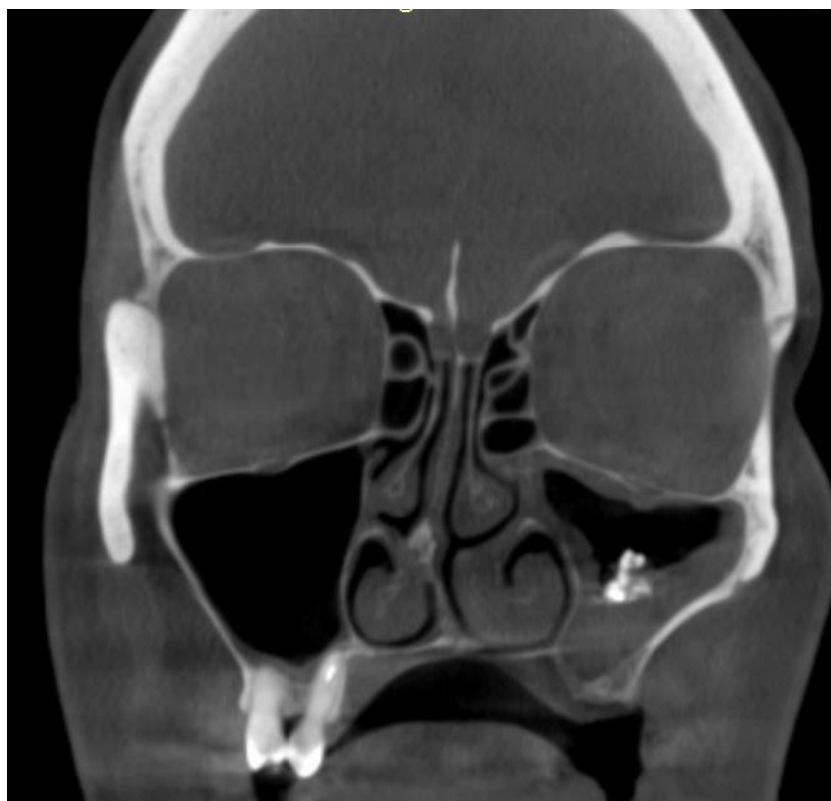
Patient D.; cone beam computed tomography of paranasal sinuses before surgery; the crest of the nasal septum, the decrease in pneumatization of the left maxillary sinus and the shadow of high density in the middle sections of the sinus (filling material and dense fungal inclusions) are determined
